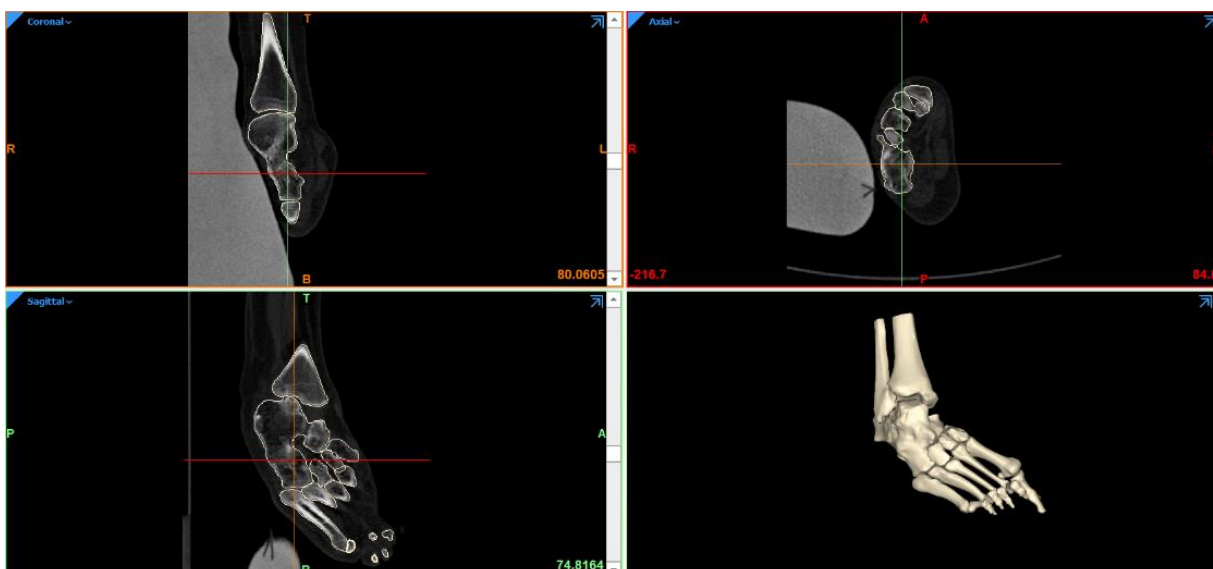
CT data of the supinely aligned preoperative foot of case A. Coronal (top left), Axial (top right) and Sagittal (bottom left) multiplanar reconstructed (MPR) views of CT data. The 3D model constructed from CT data is shown in the bottom right corner.
